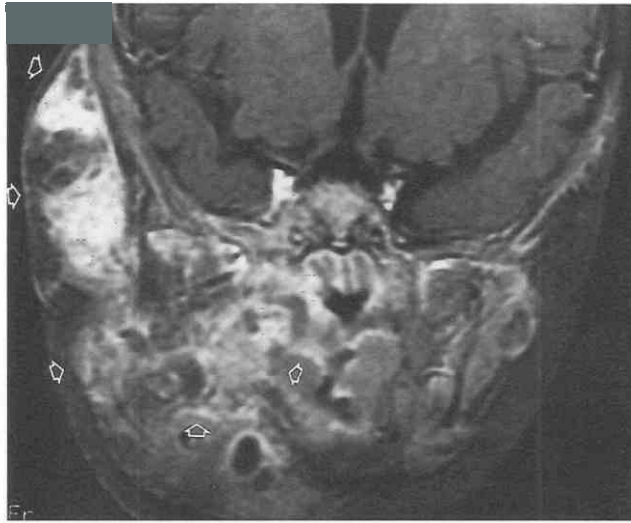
Plexiform neurofibroma. Coronal T1-weighted, postcontrast MRI scan with fat saturation. The majority of the right masticator space is involved with an ill-defined, heterogeneously enhancing mass (open arrowheads) in this patient with neurofibromatosis.
